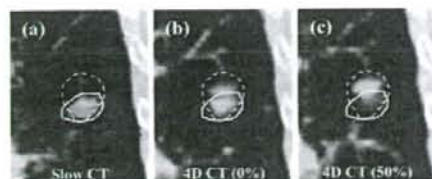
Coronal images for case 32. Left: slow CT scan. Middle: 0% phase of 4D CT scan. Right: 50% phase of 4D CT scan. Outlines of $TV_{slow\ CT}$ (solid line) and $TV_{4D\ CT}$ (broken line) were overlaid. Additional margins to encompass $TV_{4D\ CT}$ was 0.0, 3.4, 0.6, 5.7, 7.5, and 0.0 mm for lateral, medial, ventral, dorsal, cranial, and caudal directions, respectively.
